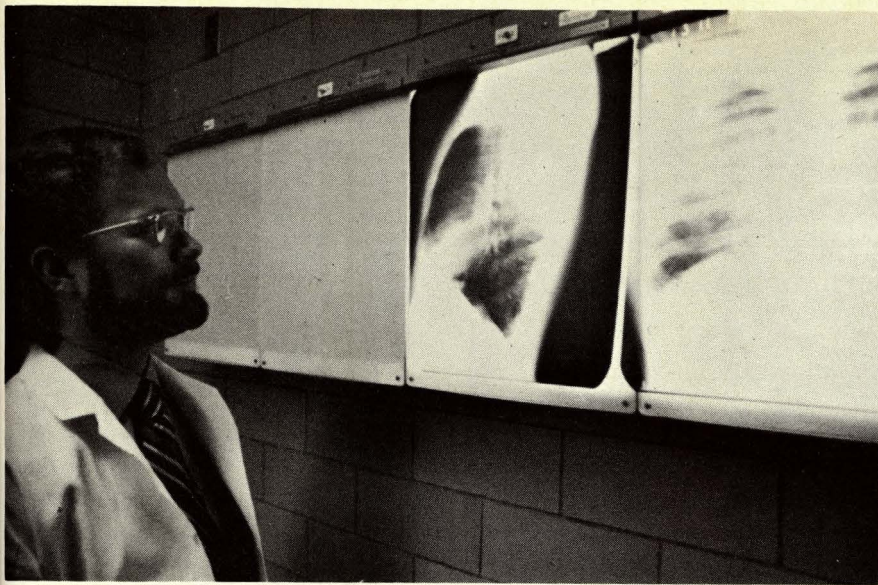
shows the author, Dr. Morgan, examining a chest X-ray as part of an employee's preplacement examination—part of an over-all medical program to help prevent cases of occupational disease.
